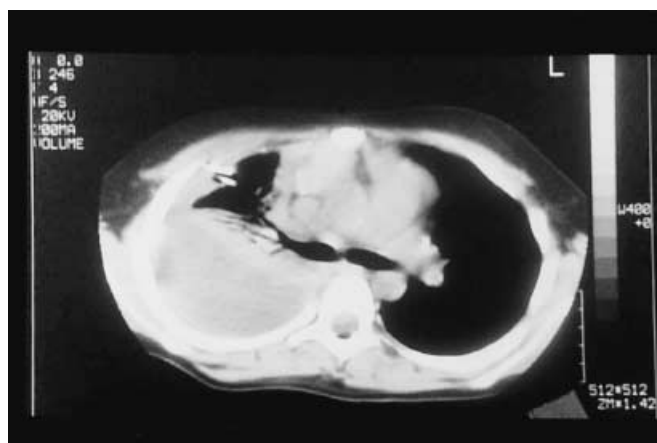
A CT scan can solve clinical problems related to an unexplained clinical course: in this case a 4-year-old boy admitted with pneumonia developed severe hypoxaemia ($\text{PaO}_2/\text{FIO}_2$ ratio of 150). Several thoracenteses did not result in the removal of the pleural collection. CT examination showed a large right pleural effusion with non-homogeneous content; the pleural drainage was located anteriorly and unable to drain the collection; most of the lung parenchyma was compressed by the collection; correct localisation of the pleural effusion allowed the positioning of a double lumen chest tube and the intrapleural administration of streptokinase
